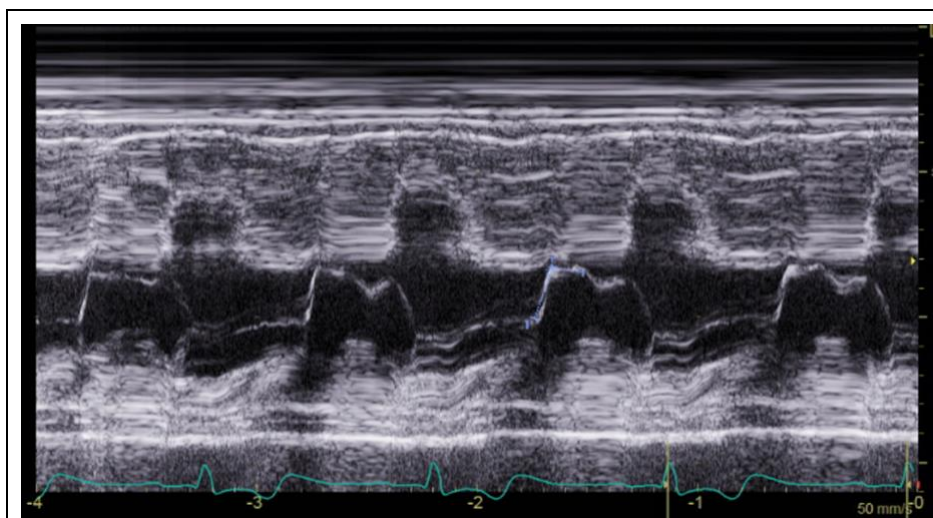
Echocardiography identified systolic anterior motion of the mitral valve.
